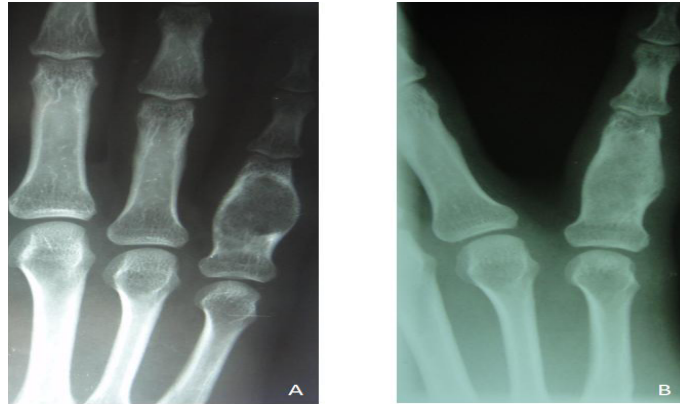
Enchondroma of proximal phalanx of fifth finger. (A) Radiographic appearance of tumor (B) 8 months after curettage and bone grafting.
